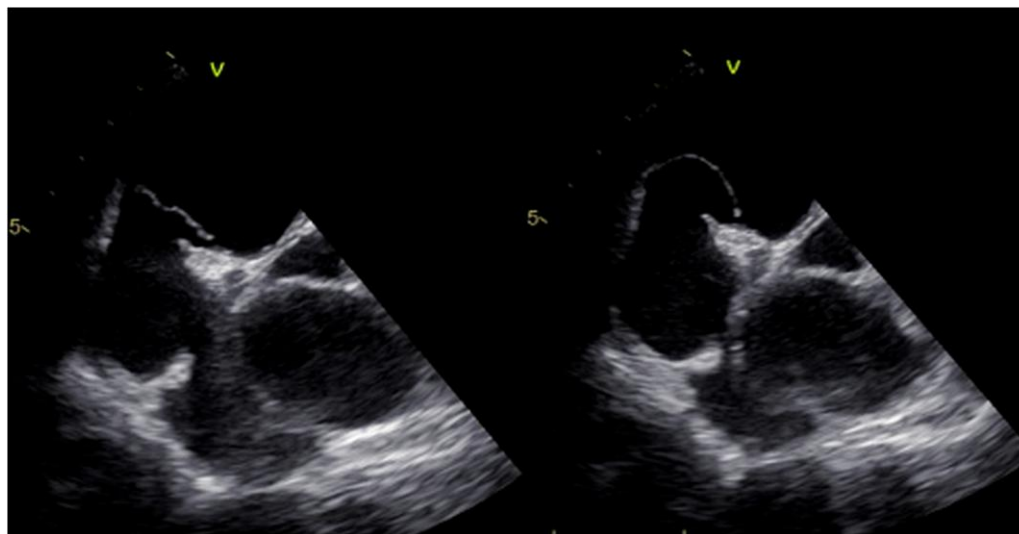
Transthoracic echocardiography of the PFO with a hypermobile atrial septum.
